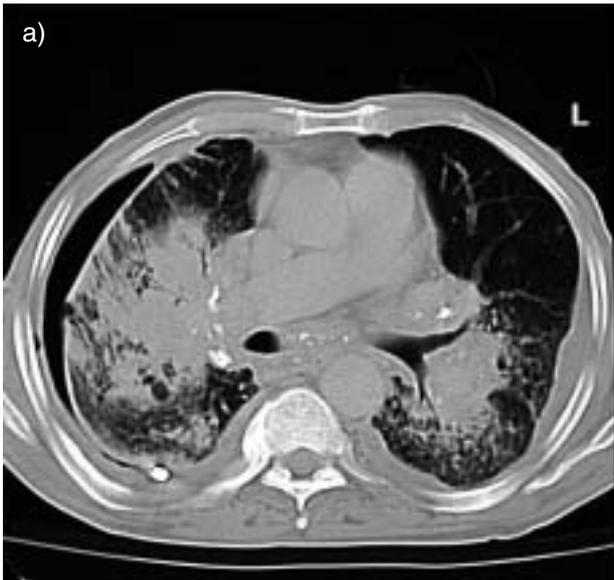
Selected cuts of computed tomographic images of the chest.
